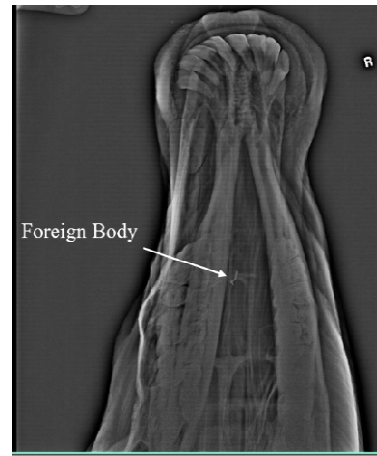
Linear Foreign Body in dorso-ventral Radiograph
